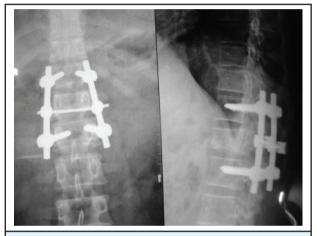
Radiograph showing a single level pedicle screw fixation with interconnector rod.
